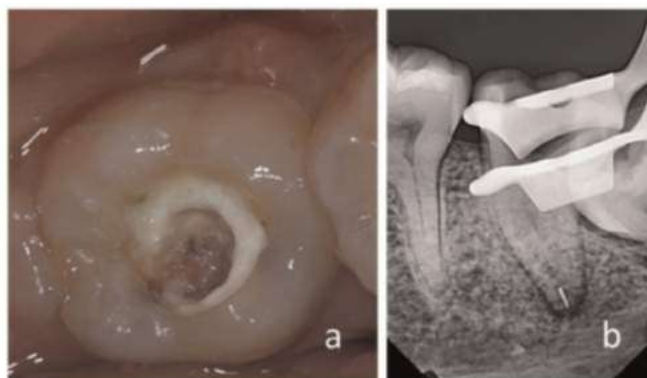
A. Preoperative clinical view of 36. B. Preoperative radiographic periapical.
